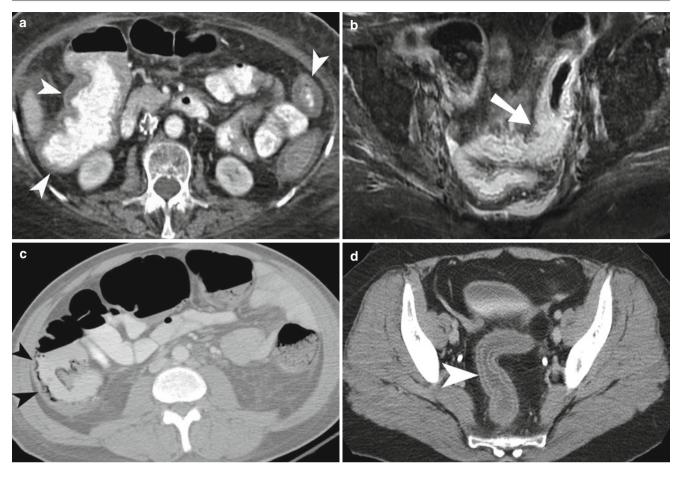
Pseudomembranous colitis. (a) Contrast-enhanced CT scan study of the abdomen demonstrates diffuse thickening of the colonic wall (*arrowheads*), more prominent on the right side. (b) Gadolinium-enhanced T1-weighted axial image of the pelvis demonstrates enhancement and thickening of the rectal as well as sigmoid colonic wall with surrounding inflammatory changes. (c) Contrast-enhanced CT shows
